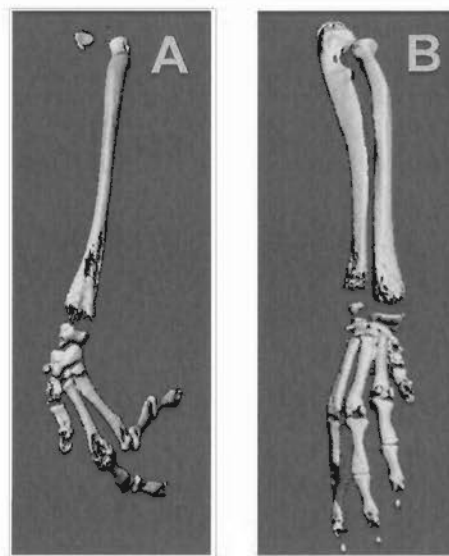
CT scanning for upper limbs
